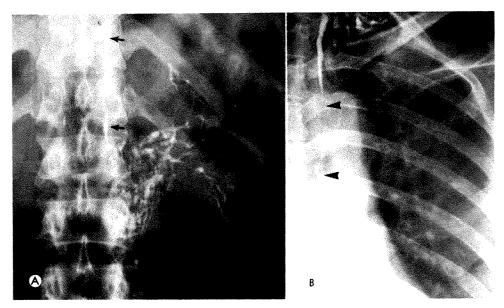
Case XIII. Roentgenograms of a 41 year old male with a 1 month history of chyluria. (A) Lymphogram showing extensive involvement of the lymphatics of the left kidney. There is filling of the abdominal part of the normal thoracic duct (arrows). (B) On a chest roentgenogram taken at the same time, the thoracic duct appeared normal in caliber (arrows); however, instead of a single channel entering the venous angle, multiple small channels filled.
